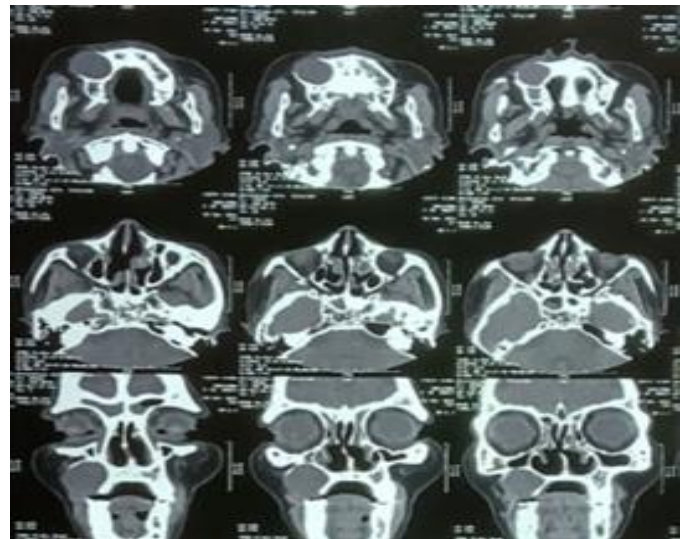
CT view of the lesion
